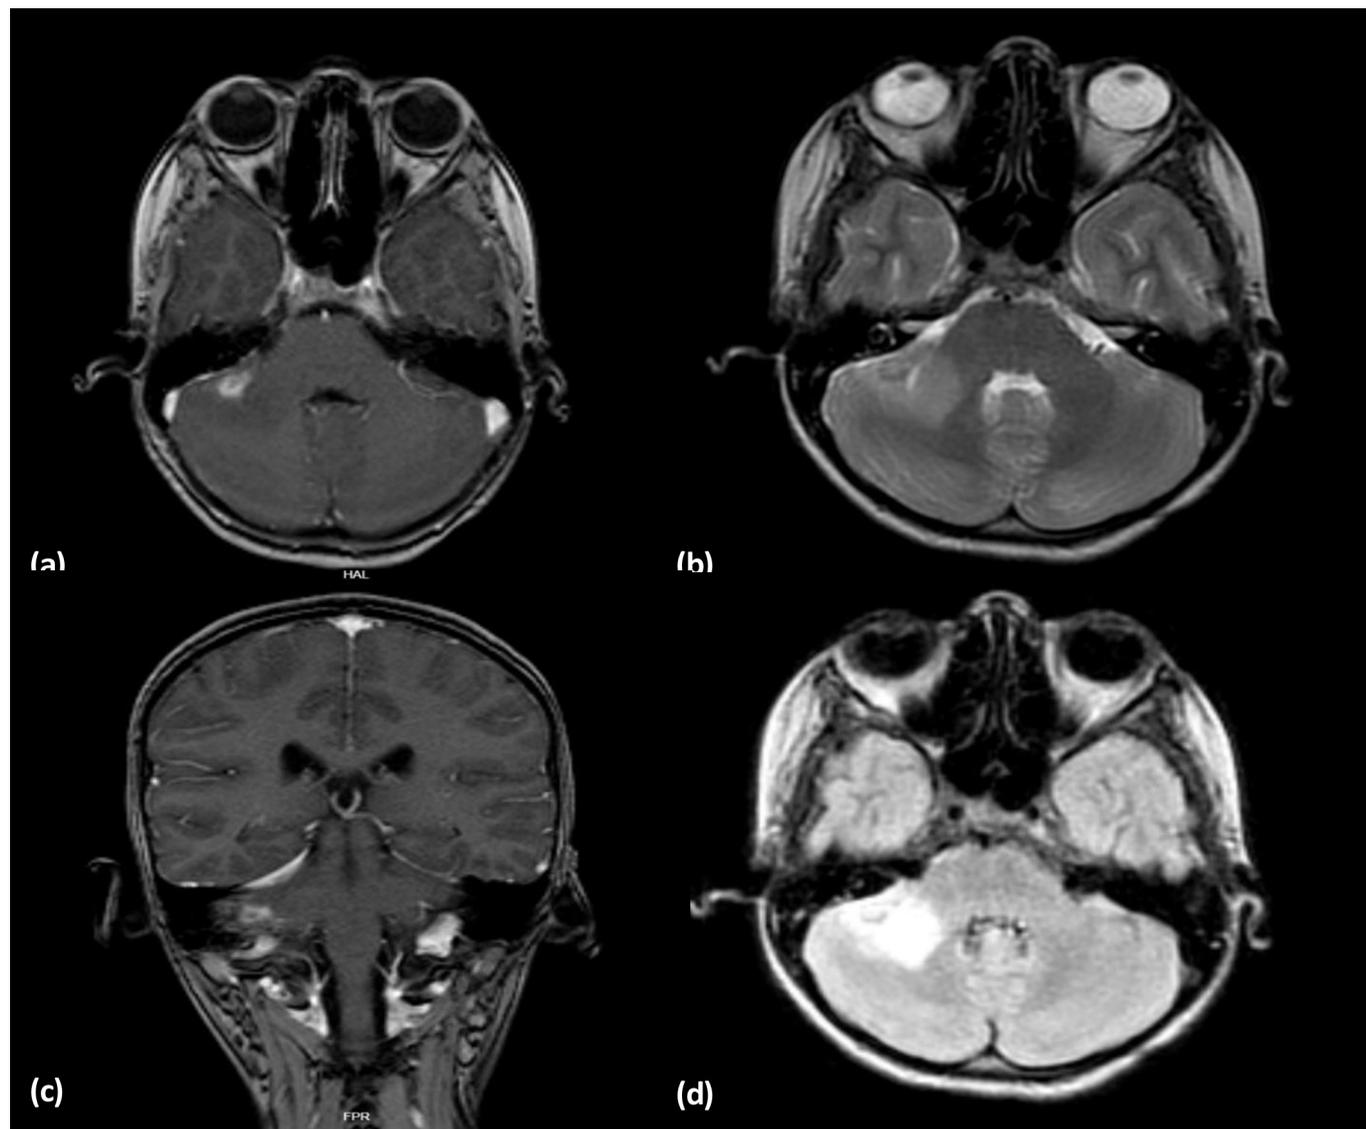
Brain MRI findings at admission. (A) Axial T1-weighted post-contrast image showing focal leptomeningeal enhancement and space-occupying lesion in the right cerebellar hemisphere. (B) Axial T2-weighted sequence demonstrating hyperintensity in the posterior fossa. (C) Coronal T1-weighted postcontrast image highlighting enhancement in the right cerebellar region and mild compression of the fourth ventricle. (D) Axial FLAIR sequence showing vasogenic edema surrounding the cerebellar lesion.
